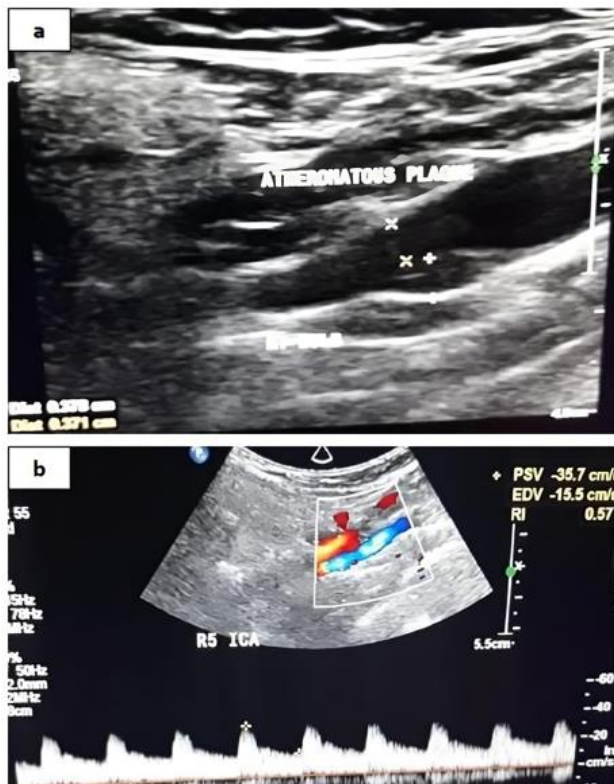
Doppler ultrasound examination: (a) B-mode Doppler ultrasound examination revealed moderate stenosis of right internal carotid artery by an atheromatous plaque; (b) color Doppler ultrasound examination of right internal carotid artery after endarterectomy showing color flow with average PSV & EDV (reprinted with permission of the patient)
